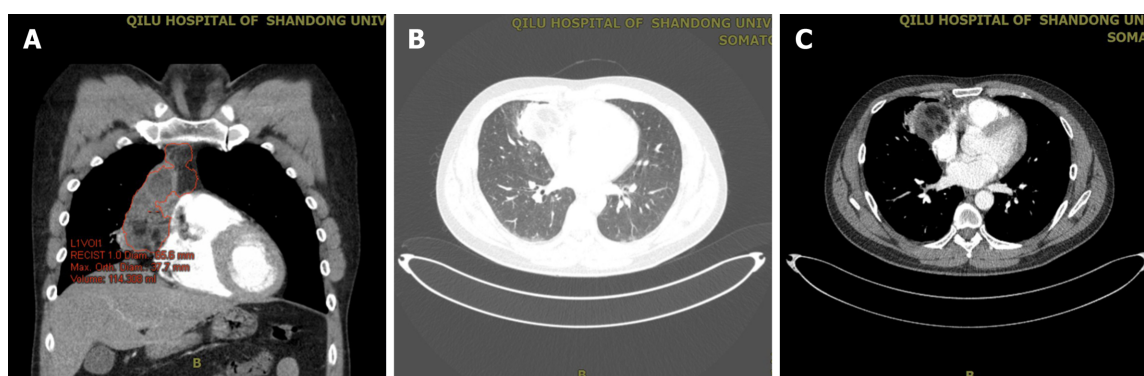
Enhanced chest computed tomography scan before surgery. A: In the coronal mediastinal window, the presence of a right hilar enlargement, an emerging cavity with high-density consolidation, high-density opacities occupying the right upper and middle lobe, diffuse high-density opacities with shadows and stripes, irregular soft tissue of mixed density in the anterior right upper mediastinum, and consolidation with cavitation and calcification adjacent to the mediastinum are shown; B: In the mediastinal window; C: In the lung window.
